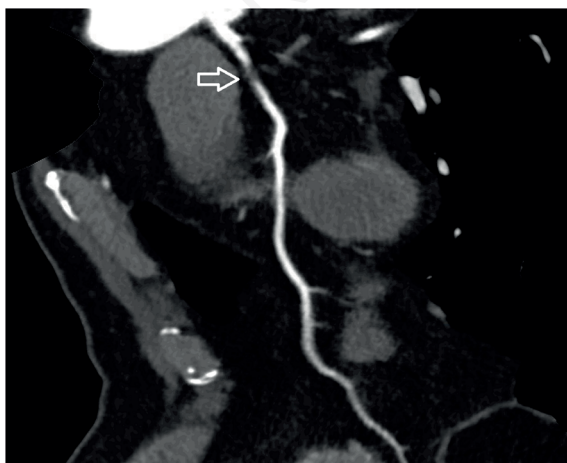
Coronary computed tomography angiography of a severe stenosis of 90% in the left anterior descending artery.
